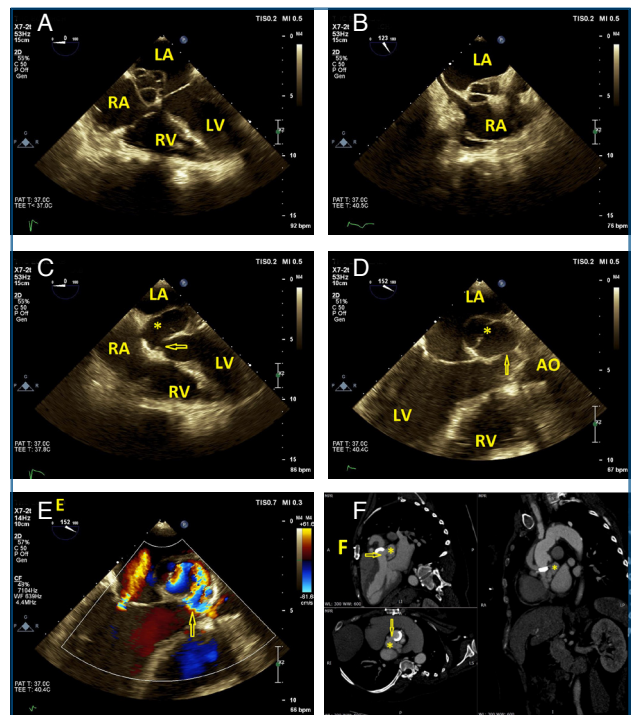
(A and B) Honeycomb appearance of the interatrial septum in the mid-esophageal 4-chamber and bicaval views of transesophageal echocardiography, respectively. (C and D) Mitral-aorta intervalvular fibrosa pseudoaneurysm (*) and its orifice (arrow) in the mid-esophageal 4-chamber view and the aortic valve long-axis view, respectively. (E) Entrance of the flow from the left ventricular outflow tract to the mitral-aorta intervalvular fibrosa pseudoaneurysm (arrow) in systole in the aortic valve long-axis view. (F) Multiplanar reconstruction of cardiac computed tomography angiography, demonstrating a space between the left atrium and the aortic tube graft with its connection to the left ventricular outflow tract, suggestive of a mitral-aorta intervalvular fibrosa pseudoaneurysm (*). AO: aortic tube graft; LA: left atrium; LV: left ventricle; RA: right atrium; RV: right ventricle.
